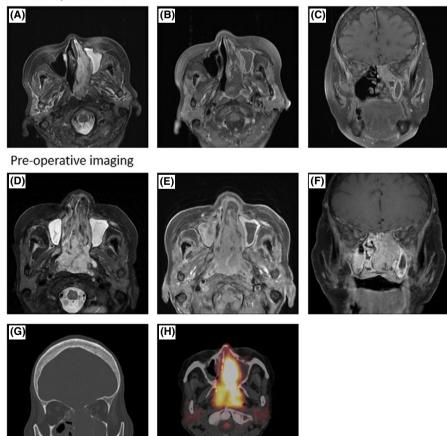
At initial presentation, axial fat-suppressed T2-weighted (A), axial fat-suppressed postcontrast T1weighted (B), and coronal fat-suppressed postcontrast T1-weighted (C) MR images show a heterogeneous left sinonasal mass with extension into the nasopharynx and associated obstructed secretions in the left maxillary sinus. Two months later, axial fat-suppressed T2-weighted (D), axial fat-suppressed postcontrast T1weighted (E), and coronal fat-suppressed postcontrast T1-weighted (F) MR images show interval enlargement of enhancing sinonasal tumor. Coronal CT image (G) shows erosions in the left medial orbital wall and ethmoid roof associated with the sinonasal mass. Axial 18 FDG-PET/ CT imaging (H) shows that the sinonasal mass is markedly hypermetabolic
